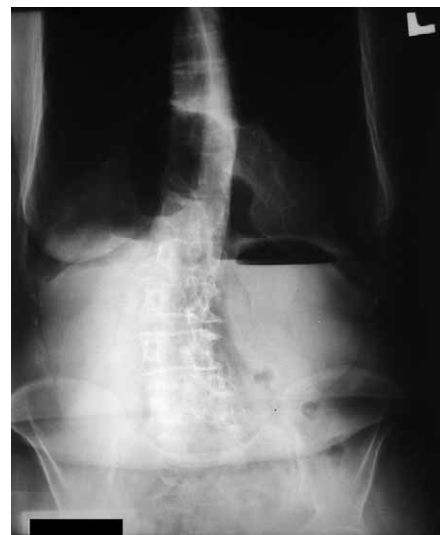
Initial recorded plain abdominal X-ray picture standing.
